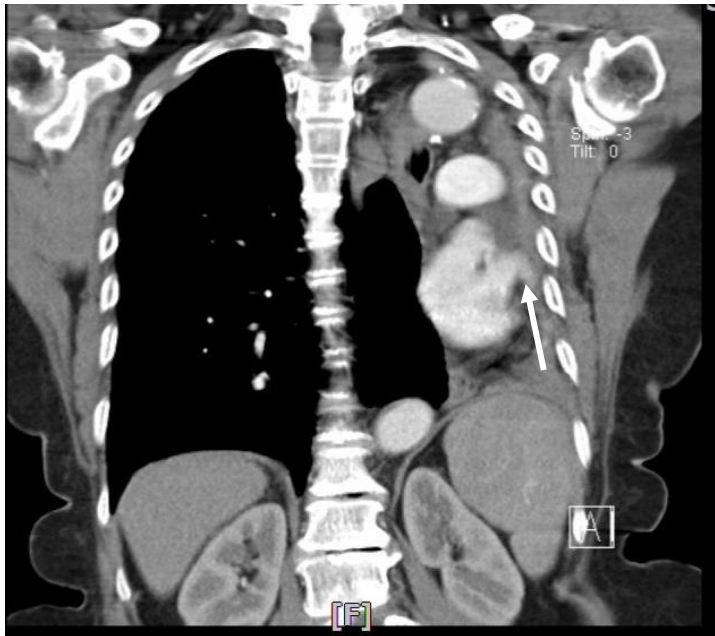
Contrast enhanced coronal CT Thorax showing the tracheal and mediastinal shift to the left with absent of the left lung parenchyma. Small left pulmonary artery seen (Arrow)
